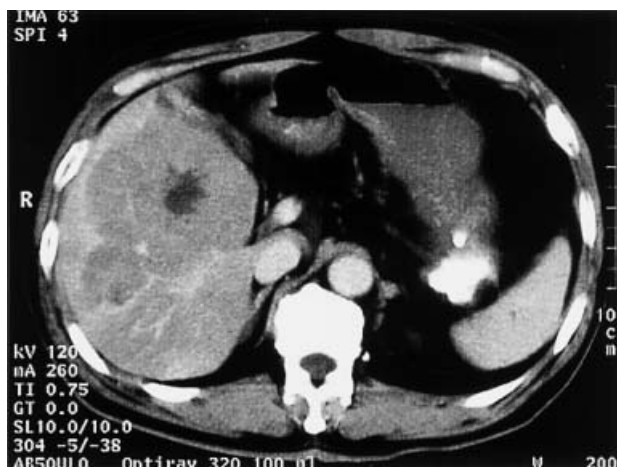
CE-CT showed multiple low-density tumors in the liver.
